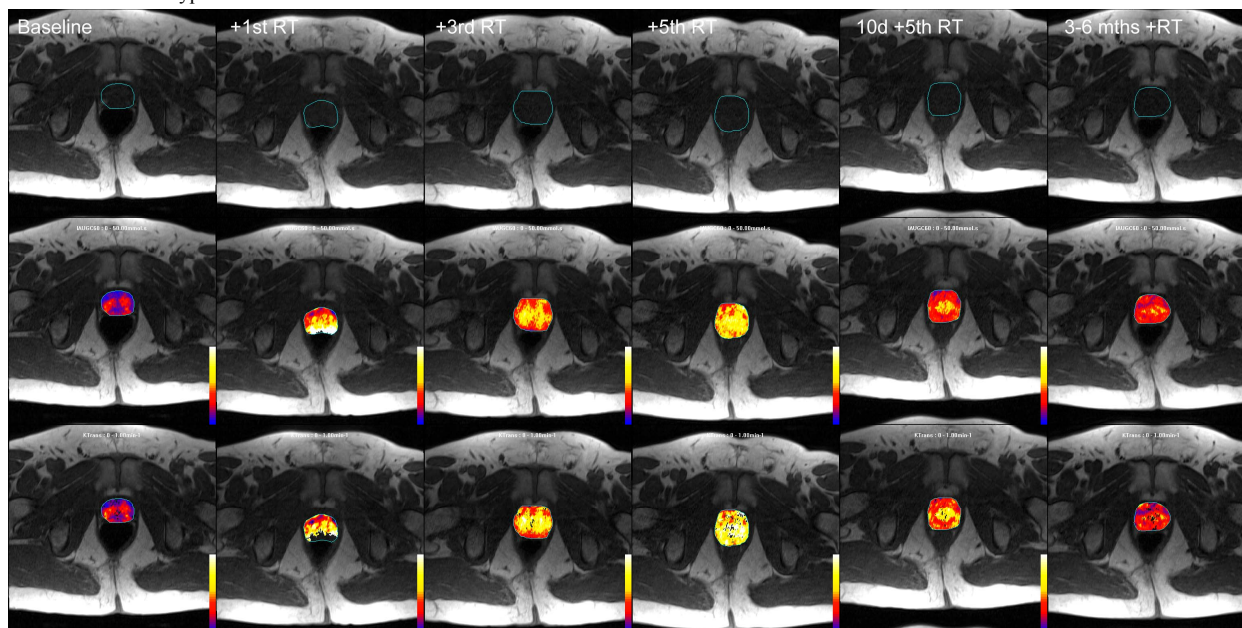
DCE-MRI images for 6 scans.
